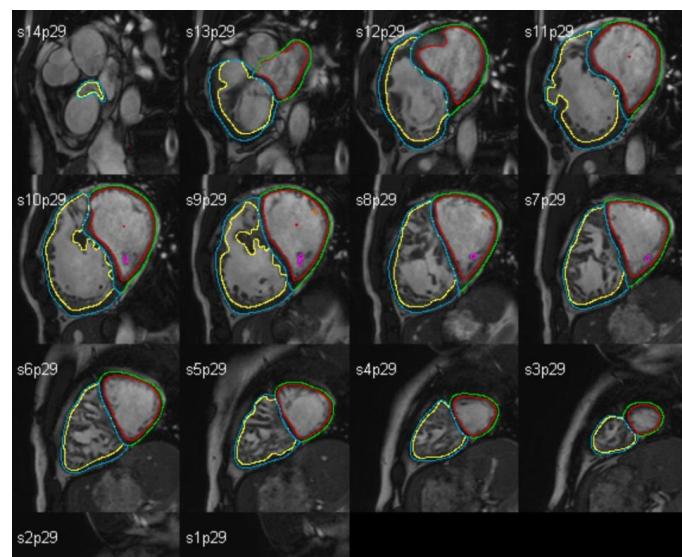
Contouring data overlay on MRI data.
